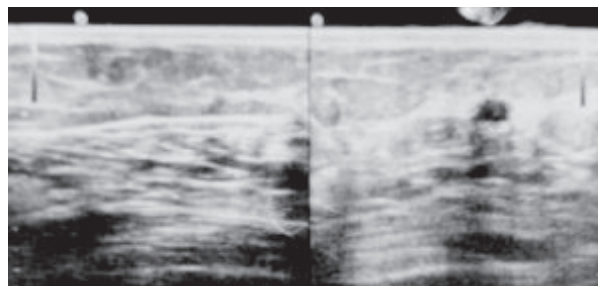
Ultrasonogram on both breasts on 25th January 2021
